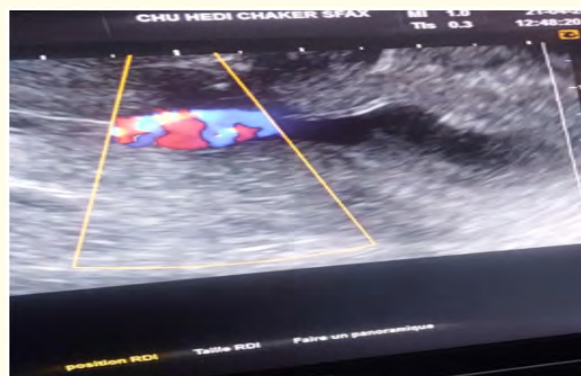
Turbulent appearance of pseudoaneurysm on color Doppler.
